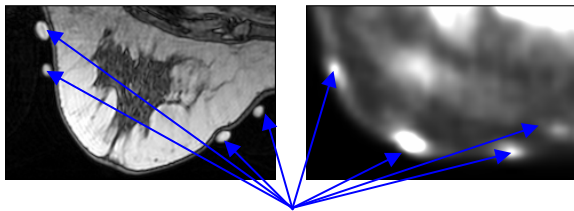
Fiducial skin markers indicated by arrows visible on MRI and PET breast surfaces in axial view.
